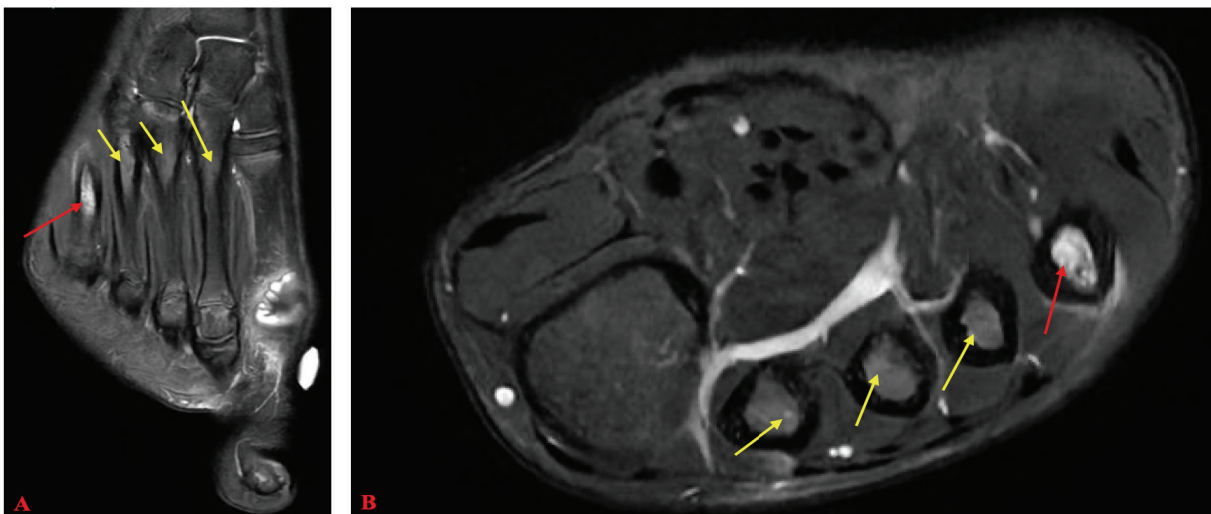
T2 axial (A) and T2 coronal (B) MRI images revealing edema related to 5th metatarsal stress fracture (red arrows) as well as mild edema along the lateral aspects of the 2nd and 3rd metatarsal bases and 4th metatarsal metadiaphysis that may represent areas of stress response (yellow arrows).
